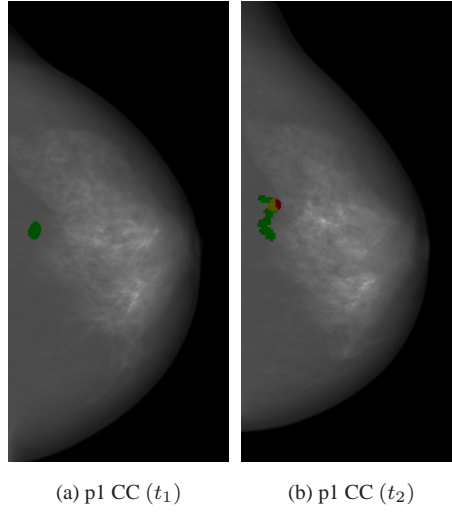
Temporal registration results for the CC view of patient p1. The X-ray annotation at timepoint t_1 is shown in green, as well as its projection on the second mammogram. The X-ray annotation of p1 at timepoint t_2 is shown in red. Their overlap is yellow. The error is $0.08mm$.
